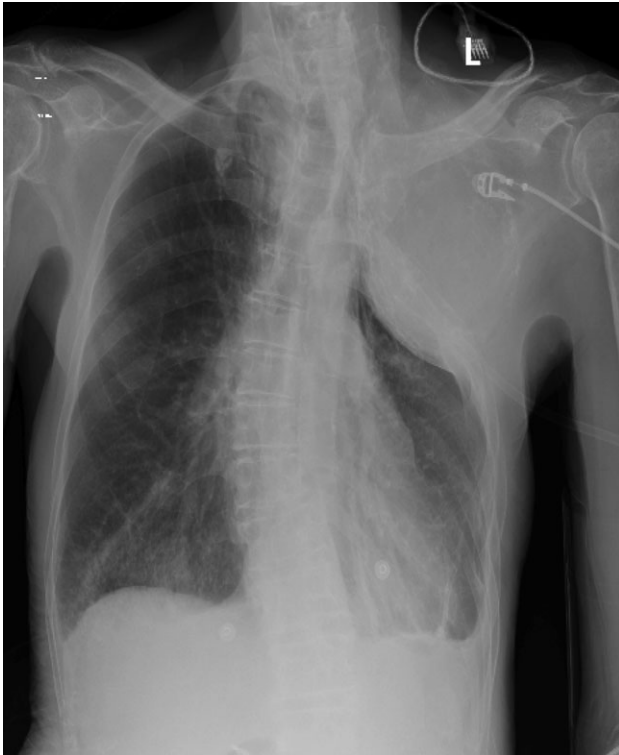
Chest X-ray notable for a large, partially calcified lung mass, measuring $\sim 16.5 \times 10$ cm, projecting over the left lung apex and likely external to the lung parenchyma.
